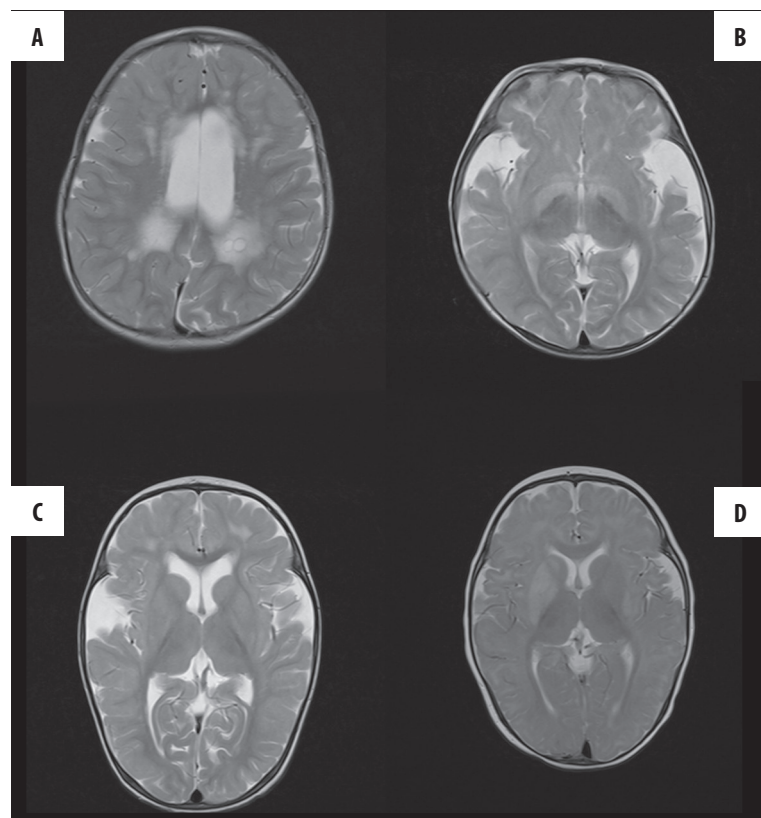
(A) Case 1, T2-weighted MRI at 4 months of age showed widened bilateral ventricles, temporal atrophy, abnormal high signals in the frontal lobe, abnormal high signals and cystic lesions in the bilateral parietal and occipital lobes. (B) Case 2, T2-weighted MRI at 30 months of age revealed obvious temporal lobe atrophy and abnormal high signals in the lentiform nucleus, widened sylvian fissures (characteristic bat wings appearance). (C) Case 3, T2-weighted MRI at 27 months of age. Multi patching signals in the white matter and frontotemporal atrophy and widened sylvian fissures (characteristic bat wings appearance). (D) Case 4, T2-weighted high signals in the right basal ganglia, frontotemporal atrophy and high signals in the left basal ganglia lentiform nucleus at 8 months of age.
